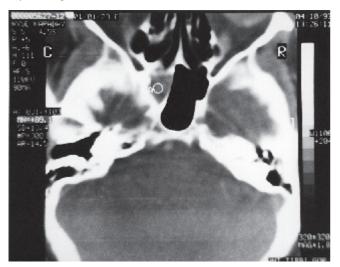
Opacity in the left sphenoid sinus on an axial CT scan.
